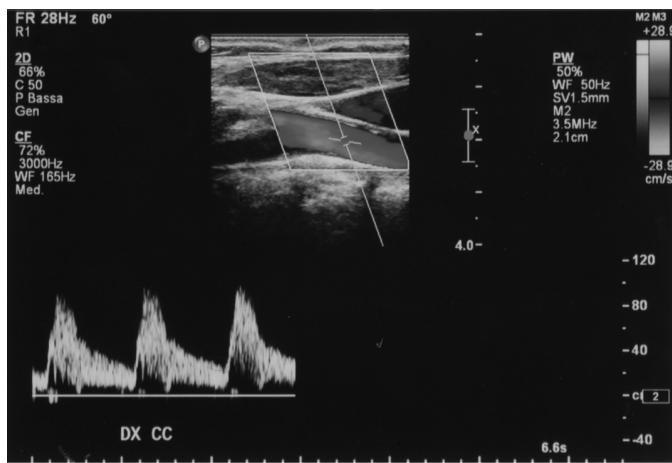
Longitudinal axis CCA - ICA (plaque, under blue color of ecoDoppler).
